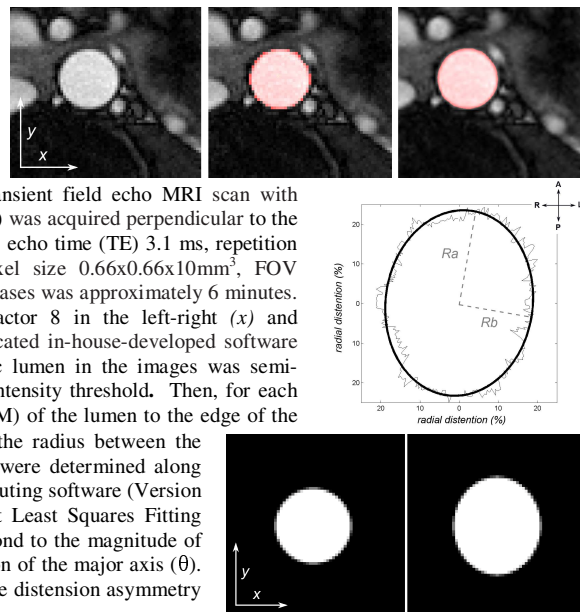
Axial single cardiac phase MR image. Supersampling (right) results in smoother segmentation (red).
